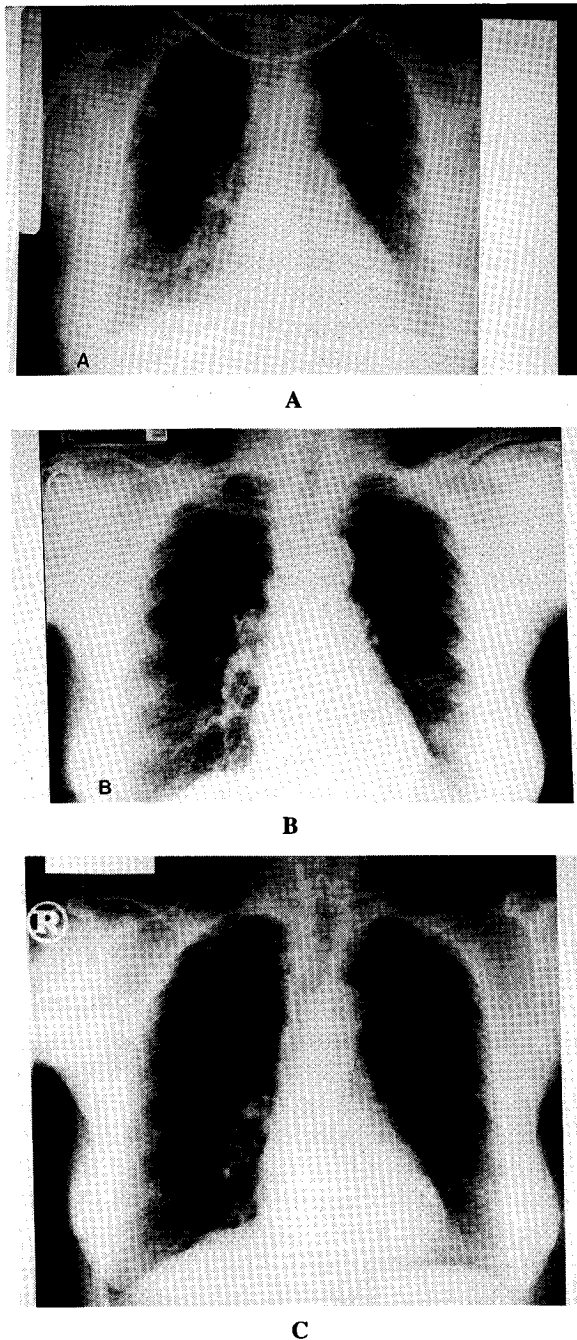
Initial chest x-ray showing a diffuse alveolar and interstitial infiltration pattern with basal accentuation (A). Chest x-rays 24 hours (B) and 6 Days (C) after drug withdrawal showing marked improvement.
